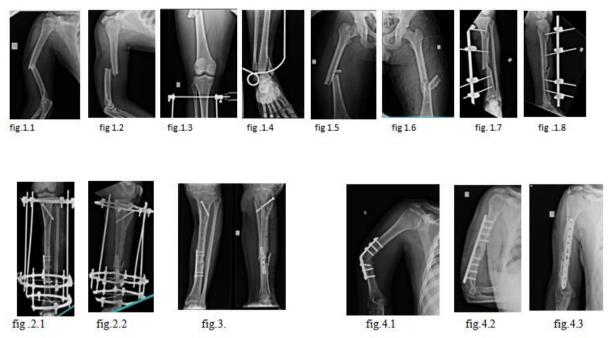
Immediate post op radiographs after both external and internal fixation of tibia(Fig.2.1,fig.2.2 Fig.3.post op radiographs taken one year after removal of Ilizarov ring fixator Fig.4.1.Implant failure of right humerus fracture, Fig.4.2,4.3 .post op xrays after 1 year follow up after revision plating
